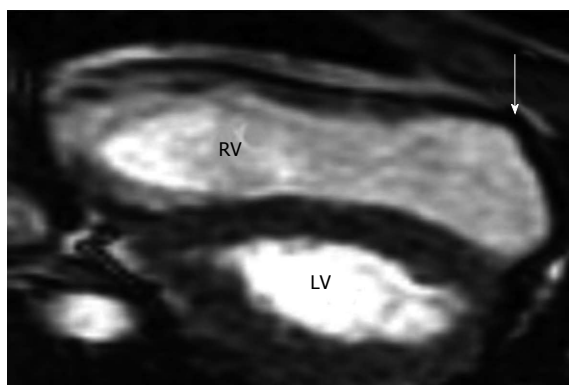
Arrhythmogenic right ventricle cardiomyopathy in a 17-year-old boy who experienced sudden cardiac death from sustained ventricular tachycardia during a soccer match and was revived with on-site defibrillation^[105]. Parasternal long-axis 2D echocardiograms obtained in end systole show a dilated right ventricle (RV) and regional dyskinesia at the RV outlet tract (arrow). LV: left ventricle.
